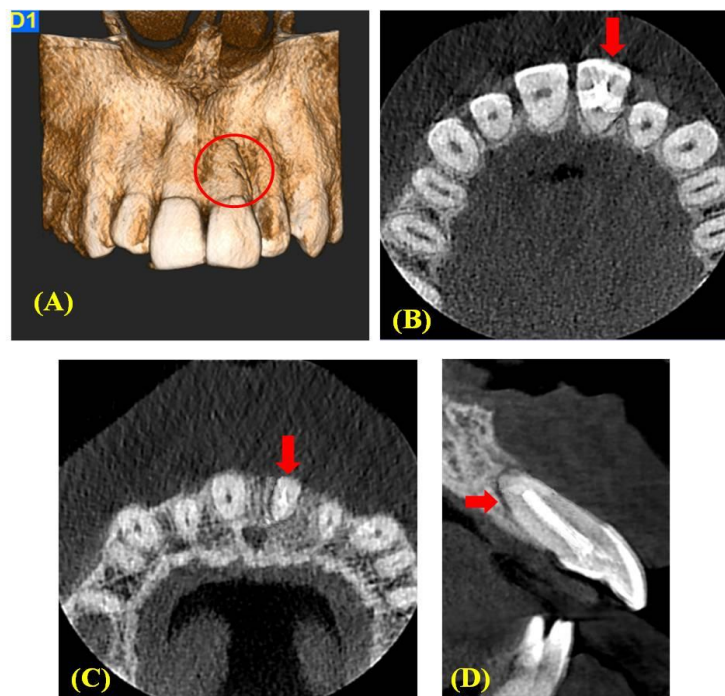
Postoperative CBCT images of tooth #21. (A) Healing seen on the mid and apical root region. Labial cortical bone in relation to 21 is regained. (B) Axial section in coronal third showing the labiolingual extent of the restored fracture line (C) Axial section in middle third showing the labiolingual healing of radiolucency (D) Sagittal section showing periradicular healing.
